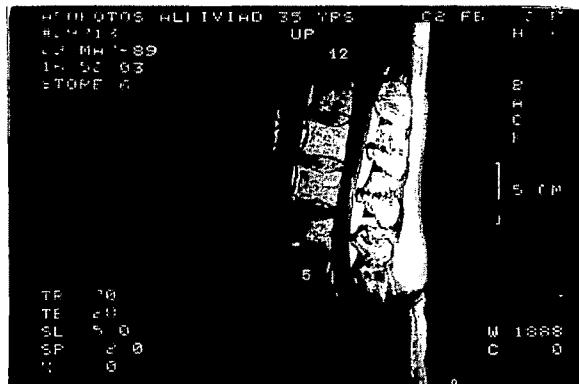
Magnetic resonance imaging of longitudinal section of lumbar spine. The lumbar vertebrae are numbered. There is no evidence of meningeal damage.
